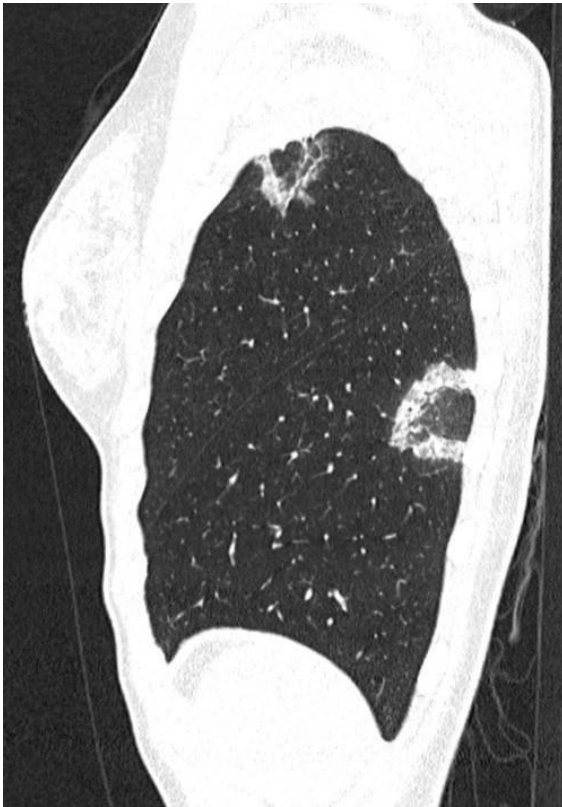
CT-scan (sagittal plane) showing two subpleural consolidation with a reversed halo sign image: 1 in the left superior lobe (31x20 mm) and 1 in the left lower lobe (45x26 mm)
